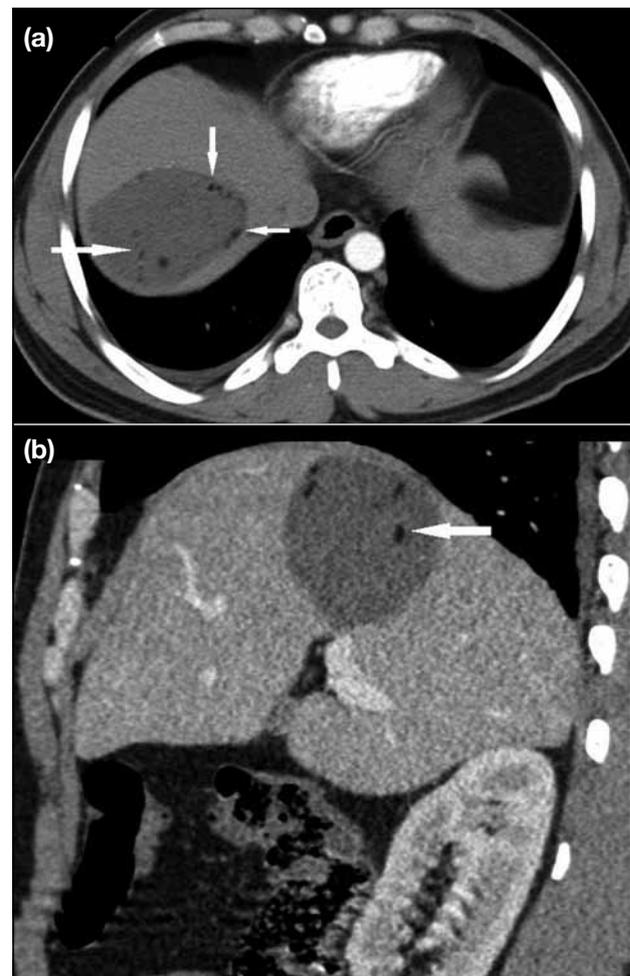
Computed tomography (CT) of case 1. (a) An axial contrast CT image shows a rounded hypodense lesion in the right lobe of the liver with globules of rounded hypodense fat attenuation foci within (arrows); and (b) a sagittal reformatted CT image shows rounded hypodense fat attenuation foci (arrow) in the right lobe liver cyst.
